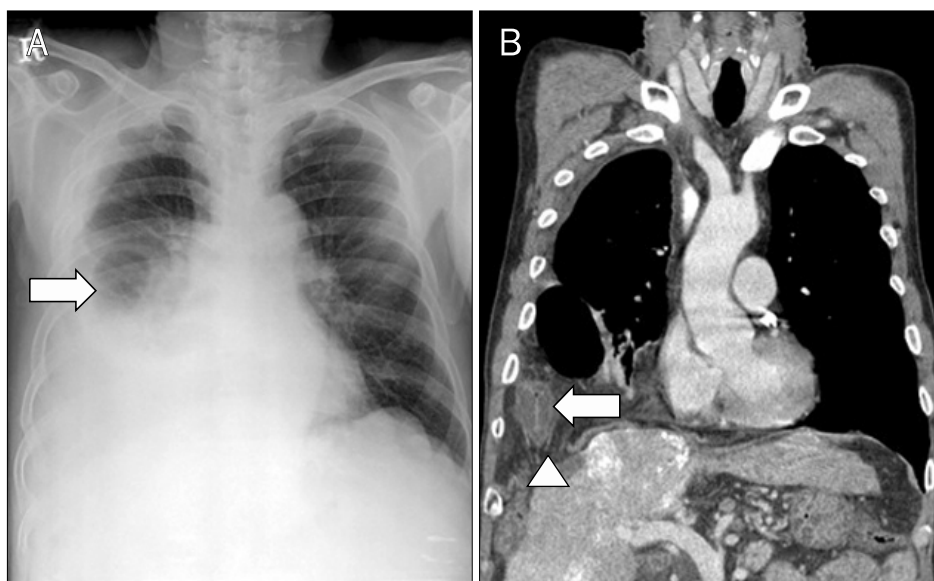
Twenty-two months after radio-frequency ablation. (A) Chest X-ray showing a large amount of pleural fluid and loops of bowel (arrow) in the right pleural cavity. (B) Coronal chest CT image showing about a 4.0 cm sized defect of the diaphragm (arrow-head) and herniation of the large intestine (arrow) in the right pleural cavity.
